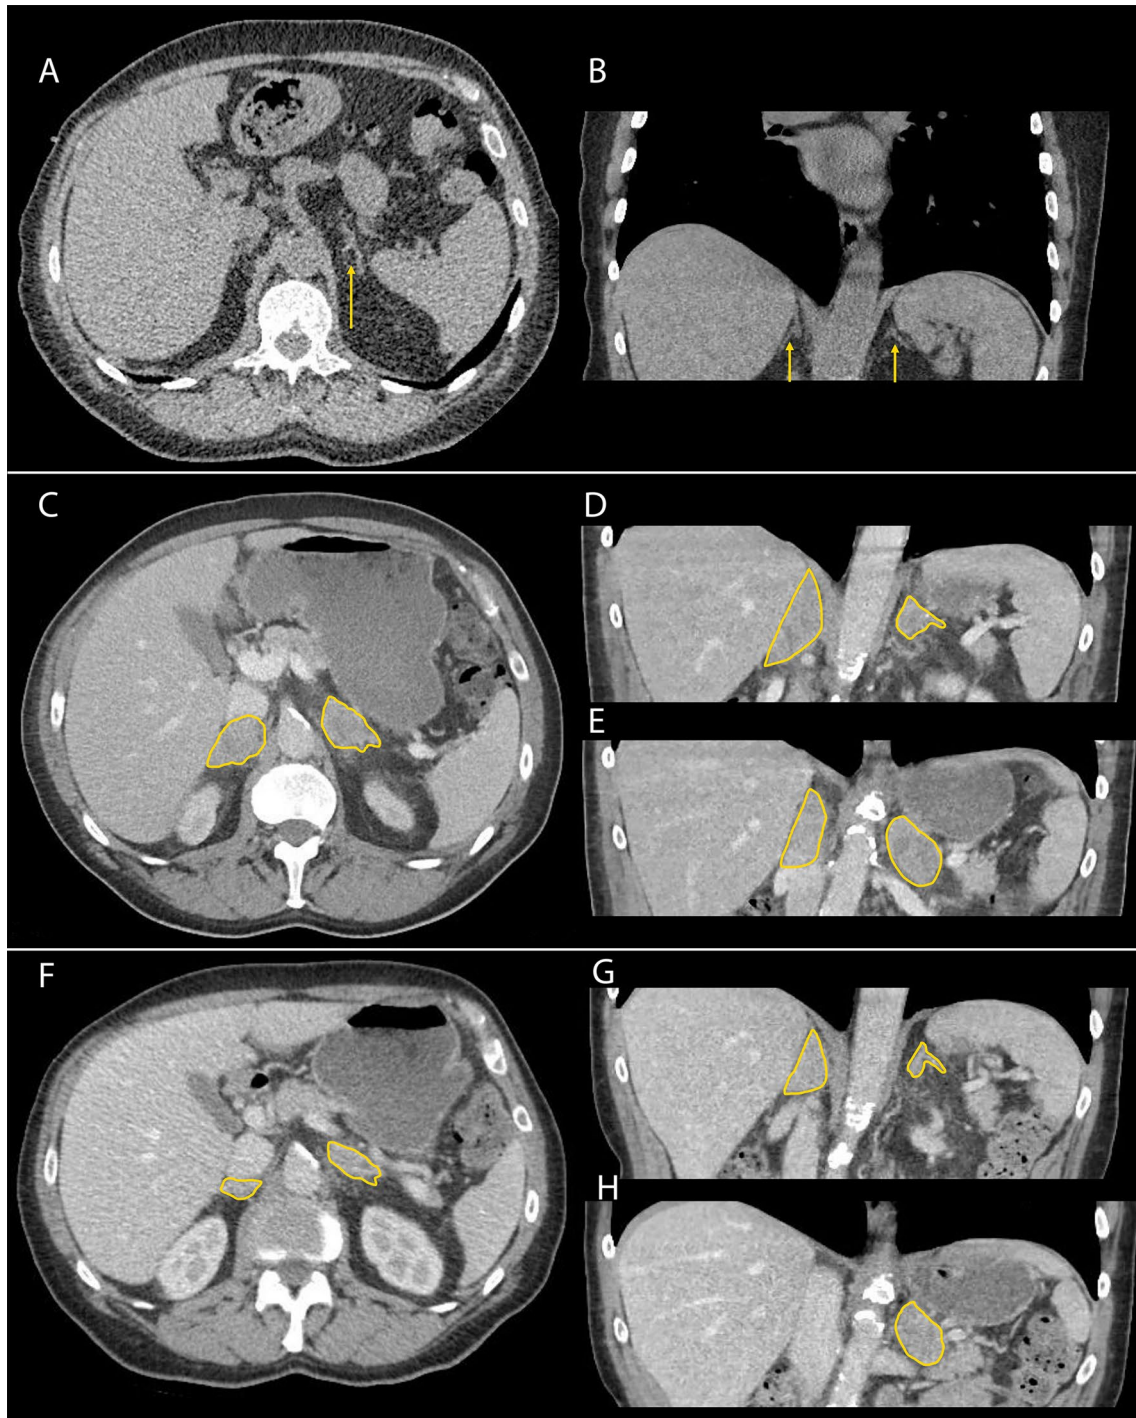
CT images of the adrenal masses. Window A (transversal plane) and window B (coronal plane): day 29, no adrenal masses on CT chest. Window C (transversal plane) and windows D and E (coronal plane): day 127, dedicated abdominal CT with contrast medium washout; adrenal masses are indicated/outlined with a yellow line. Window F (transversal plane) and windows G and H (coronal plane): day 127, dedicated abdominal CT with contrast medium washout;
